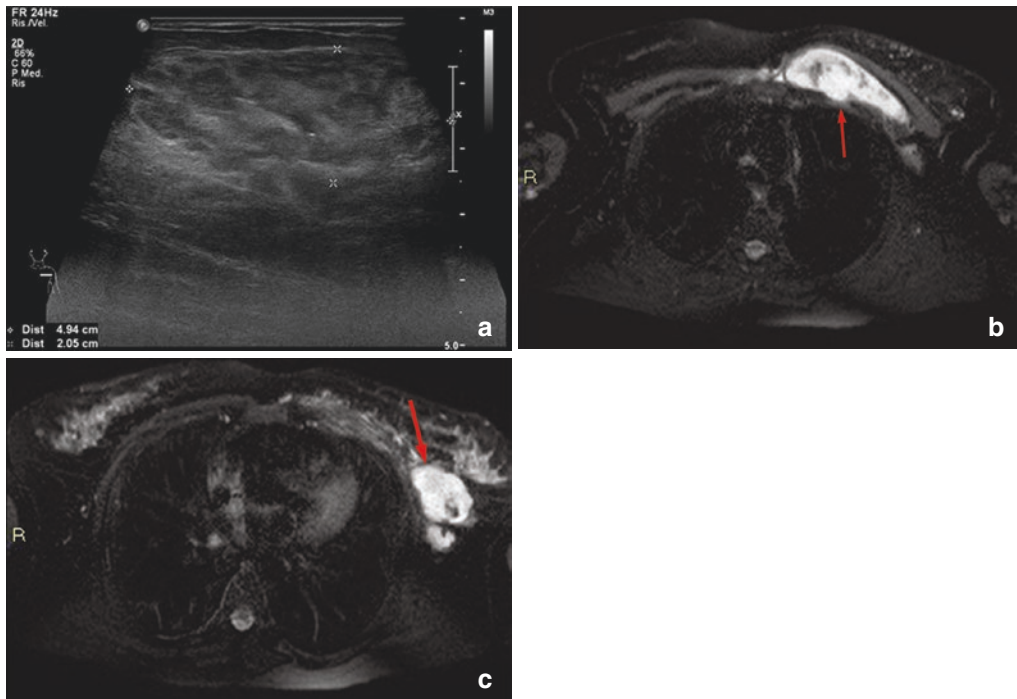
Abscess of the chest wall. The ultrasound examination (a) showed the presence of a complex mass of about 5 cm in the left subclavian space. Echostructural characteristics alone did not allow for differential diagnosis from a hematoma. The MRI (b, c) showed the subfascial seat and extension to the axilla. The hyperintense
